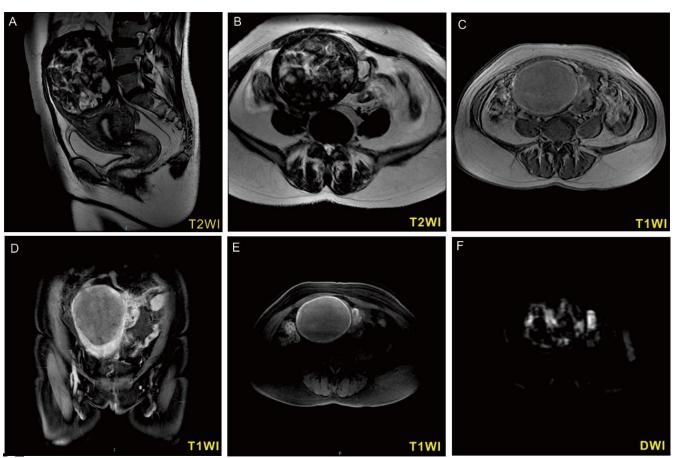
Findings of CE-MRI images of the pelvis previous to operation showed that the largest mass in the myometrium of the uterine fundus, approximately 10.4 cm × 8.5 cm × 9.5 cm, comparing to the myometrium, appeared as isointense to slightly hyperintense on T1-weighted imaging (T1WI) and heterogeneous hypointense to hyperintense on T2-weighted imaging (T2WI).
